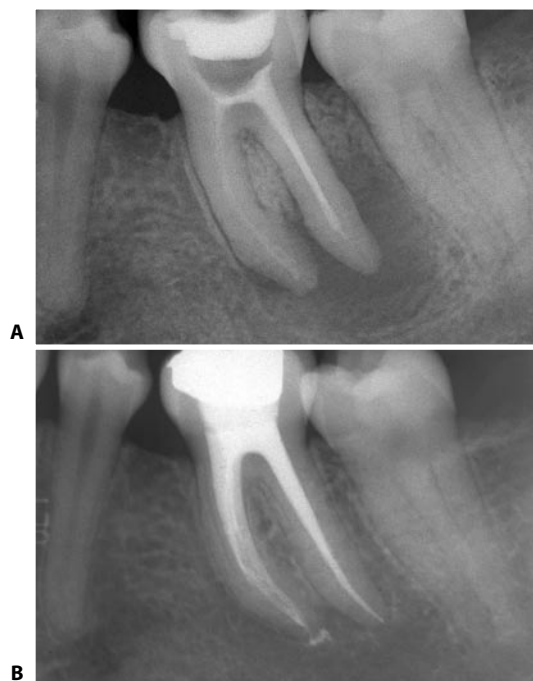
A, B. Pre-op and 24 month recall radiographs of a lower molar filled with the Continuous Wave of Condensation (Courtesy of Dr. A. Castellucci).
